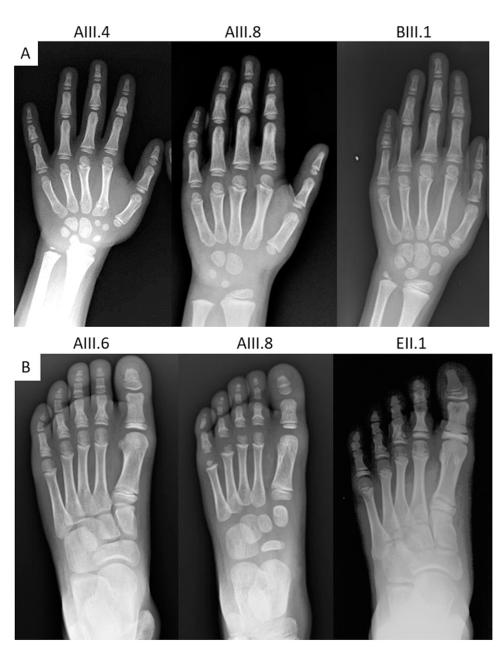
Hand and feet radiographs of children carrying heterozygous IHH mutations. (A) Hand radiographs show varying degrees of shortening of the middle phalanx of the second and fifth fingers with cone-shaped epiphyses. (B) Foot radiographs show shortening of distal phalanx of the hallux (individuals AIII.6 and AIII.8) and cone-shaped epiphyses of proximal phalanges.
